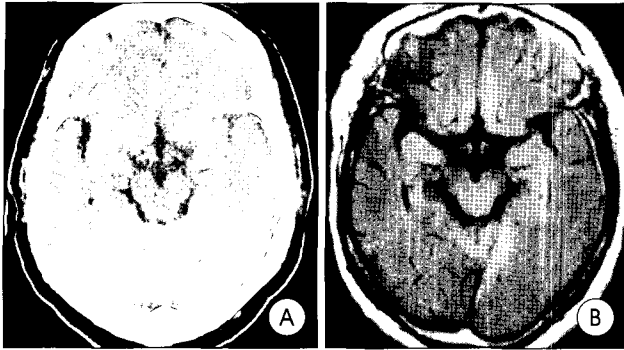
A : Brain computed tomography scan of patient 4 showing a thin subdural hematoma over the left temporal convexity and the tentorium. B : Fluid attenuated inversion recovery magnetic resonance image showing a thin subdural hematoma over the left temporal convexity and along the left tentorium. There was no evidence of subarachnoid hemorrhage.
